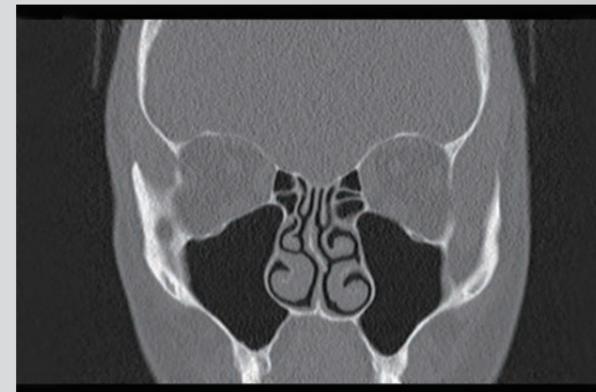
CT sinus. 0.02 mSv - 60-year-old woman. Dose: DLP 8.9 mGy-cm.
